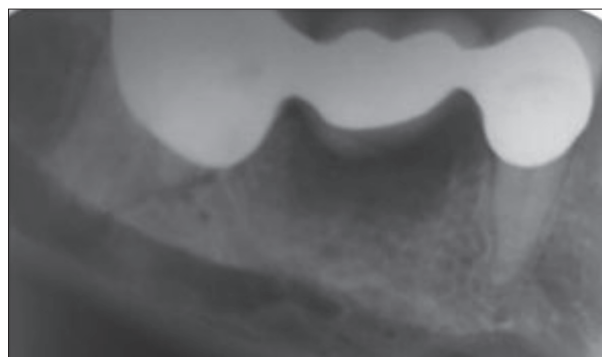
Preoperative radiography of the right side of the molar region of mandible
